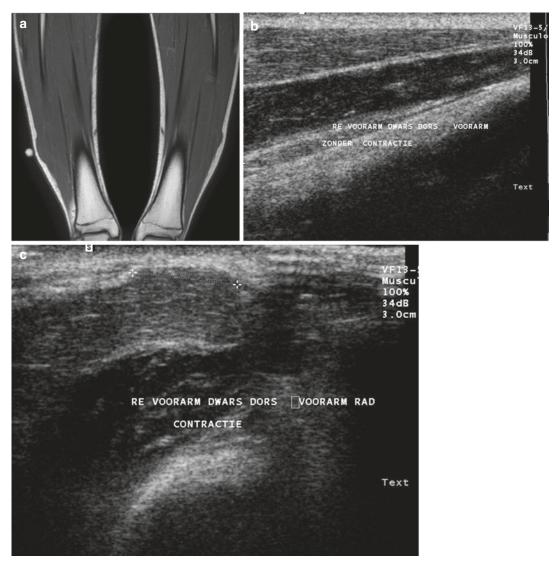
Muscle herniation in two different patients. (a) Long-standing bilateral muscle herniation in a 15-year-old male: a coronal spin echo T1-weighted MR image. A focal bulging of the peroneus muscle compartment is seen, more pronounced on the right side. As expected, this protruding mass has the same signal characteristics of normal muscle tissue (\mathbf{b}, \mathbf{c}) . Ultrasound of the forearm without (\mathbf{b}) and with muscle contraction (\mathbf{c}) in another patient. Note the presence of a mushroomshaped lesion bulging through a focal defect in the superficial fascia. The lesion is only visible with muscle contraction (\mathbf{c}) are identical to skeletal muscle on all pulse sequences, as long as there is no adjacent edema or contusion. When in doubt, a dynamic MR examination with forced dorsiflexion and plantar flexion of the ankle allows a better evaluation of the changes in shape and size of a muscle herniation [27, 118]. MR imaging of the fascial defect is possible but difficult.
